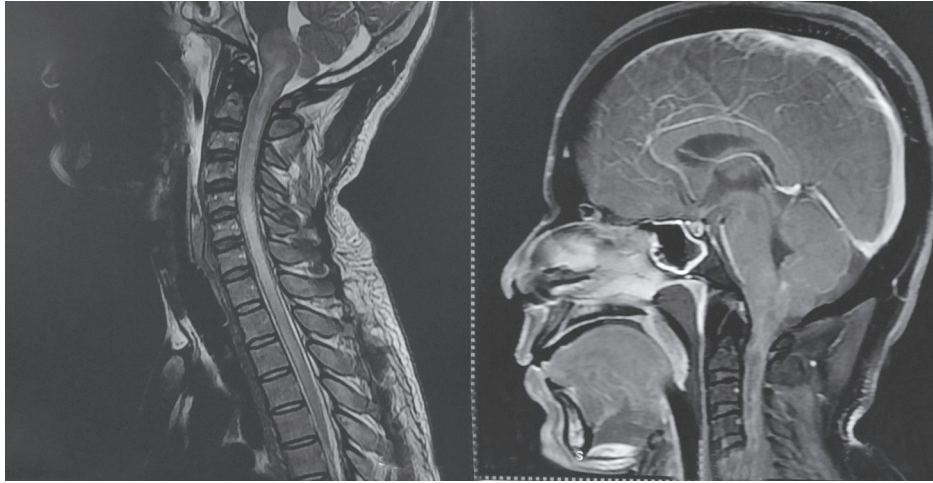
MRI T2W and postcontrast T1W sagittal showing leptomeningitis with brainstem encephalitis and rim-enhancing abscess in brainstem extending into spinal cord with rim-enhancing intraspinal abscess
